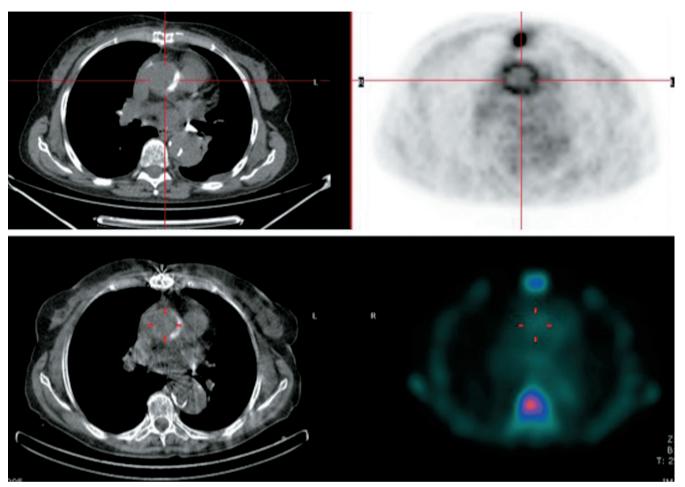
Upper images: [18F]FDG PET/CT in a patient refered for fever of unknown origin. Images show a diffuse uptake of FDG both in the aortic wall and in the recent sternotomy. Lower images: [99mTc]-HMPAO labelled WBC with SPECT/CT acquisition at 20 h post injection in the same patient, showing no uptake in the aortic valve and moderate, physiological uptake in the sternotomy (false positive of [18F]-FDG PET/CT).
